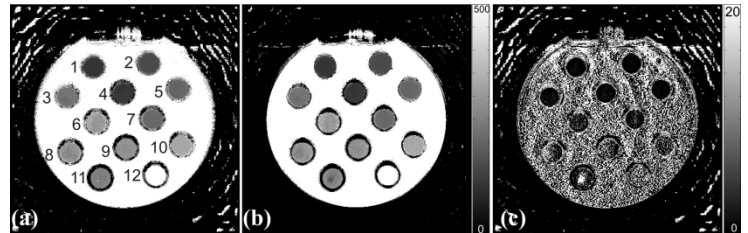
T2 maps obtained from ME-FSE MR images obtained using (a) fully sampled data and (b) proposed technique. The difference between the two is shown in (c)
